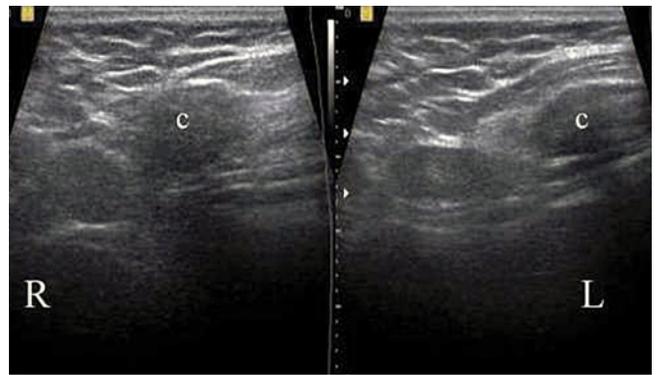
Slipping rib syndrome. Comparative sonogram showing dislocation of right rib 8 slipping towards rib 7 (R), revealed during Valsalva maneuver. No such effect was demonstrated on the left side while performing the same maneuver (L).
